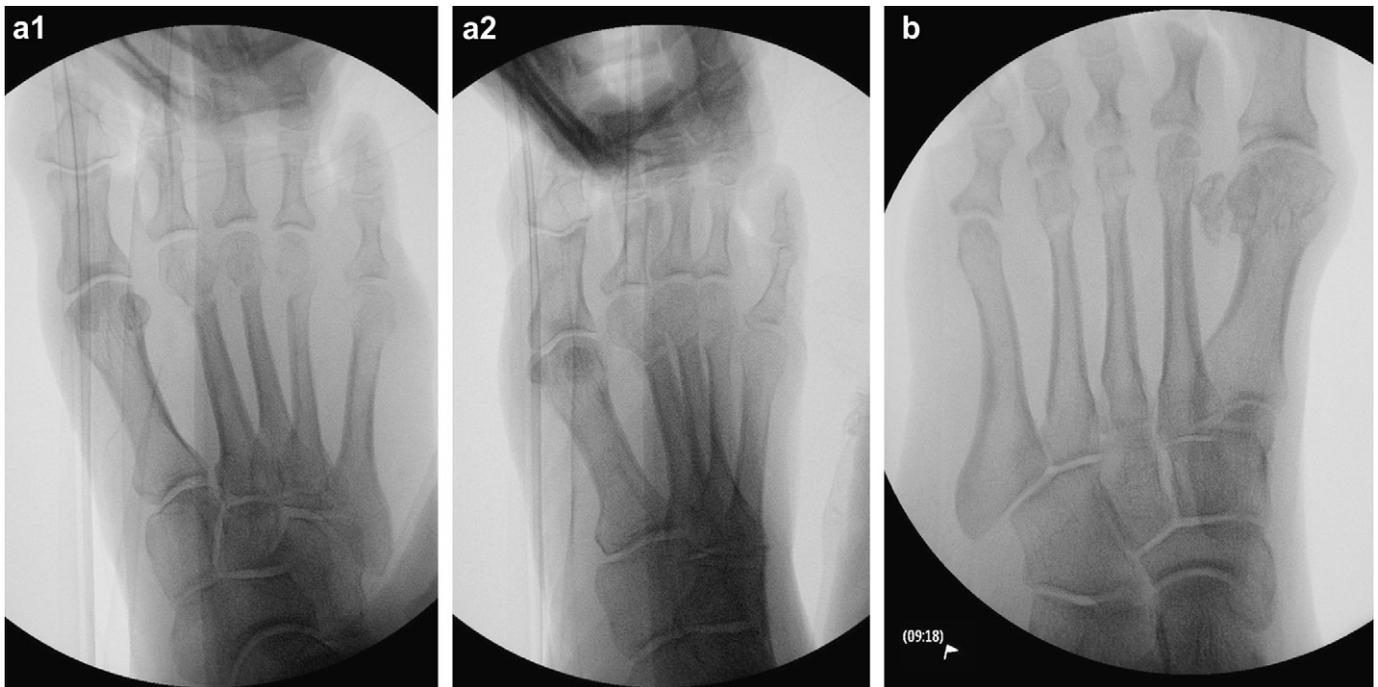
Intraoperative radiographs showing orientation of osteotomies: (a) case 1, (b) case 2.
